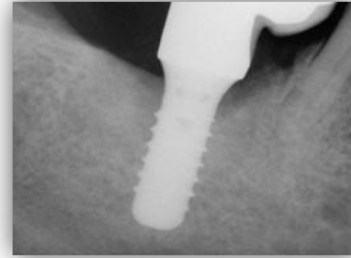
9-Month Post-Operative Radiograph
